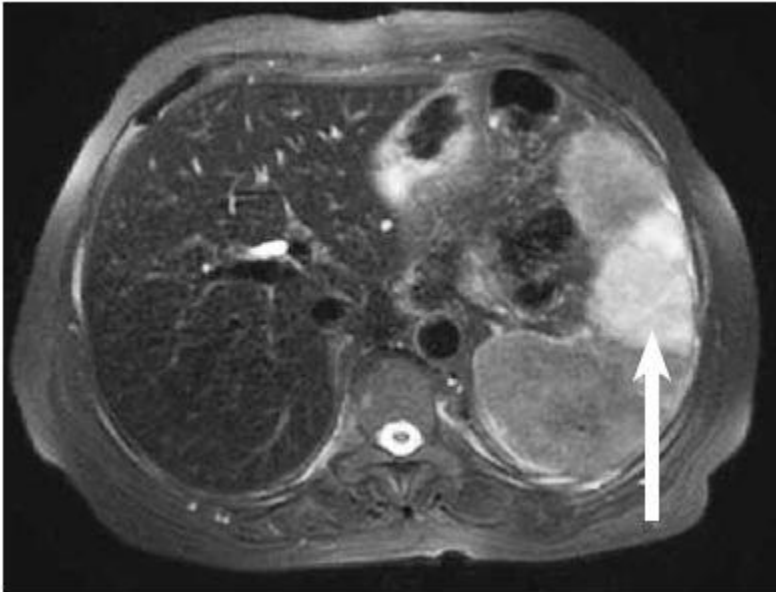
shows axial T2 MRI image for the spleen (Benjamin-2012)
